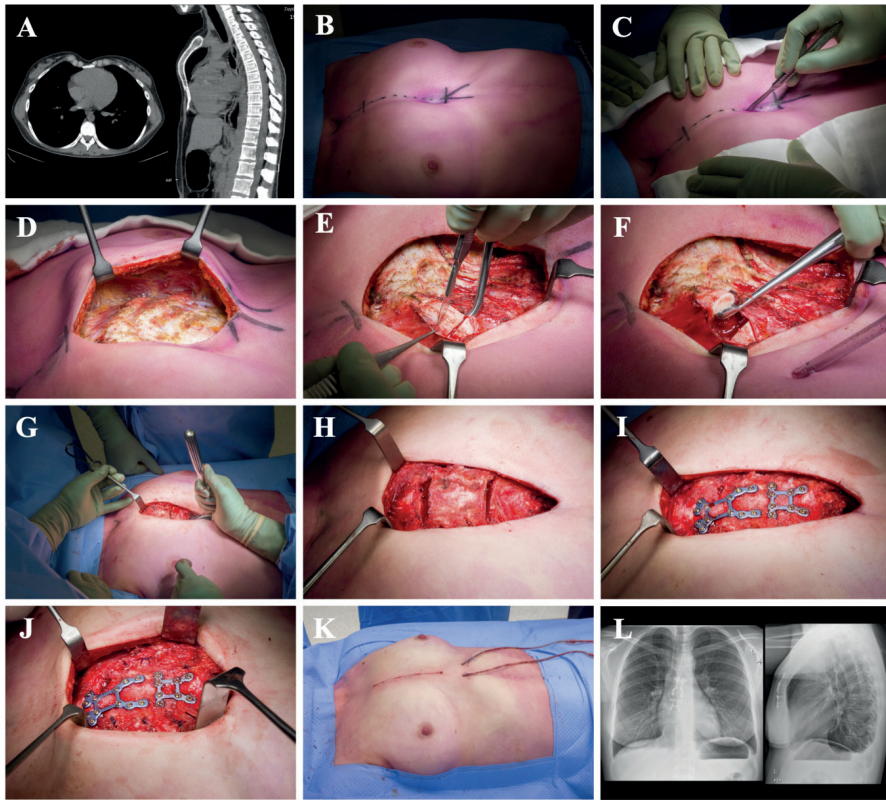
Surgical technique of the modified Ravitch procedure. (A) Preoperative evaluation by computed tomography. (B) Identification of the deepest point and incisional site. (C) Skin incision. (D) Bilateral pectoralis muscle dissection to expose the sternum and affected rib cartilage. (E-F) Resection of the deformed cartilage with preservation of the perichondrium. (G) Xiphoidectomy and sternal elevation. (H) Sternal osteotomies. (I) Fixation of the sternal osteotomies by the SternaLock Blu system. (J) Approximation of the perichondrium. (K) Placement of low-vacuum drains and closure in layers. (L) Postoperative result.
